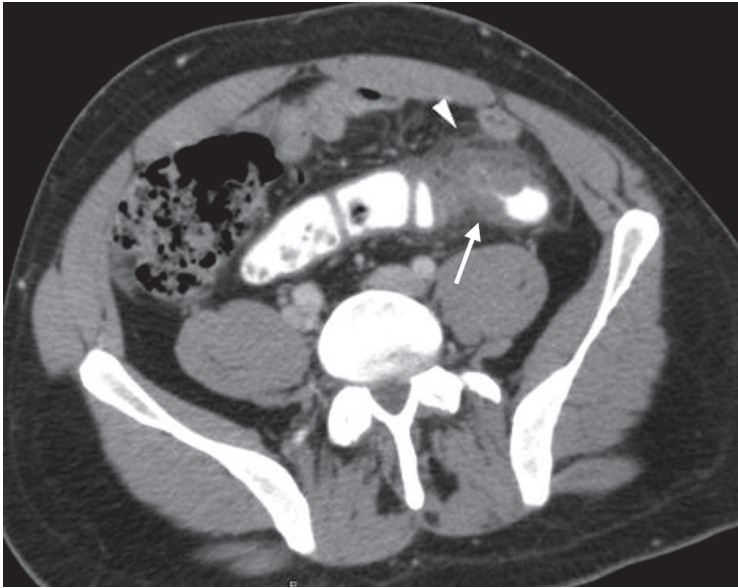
CT abdomen with sigmoid wall thickening and adjacent fat stranding
